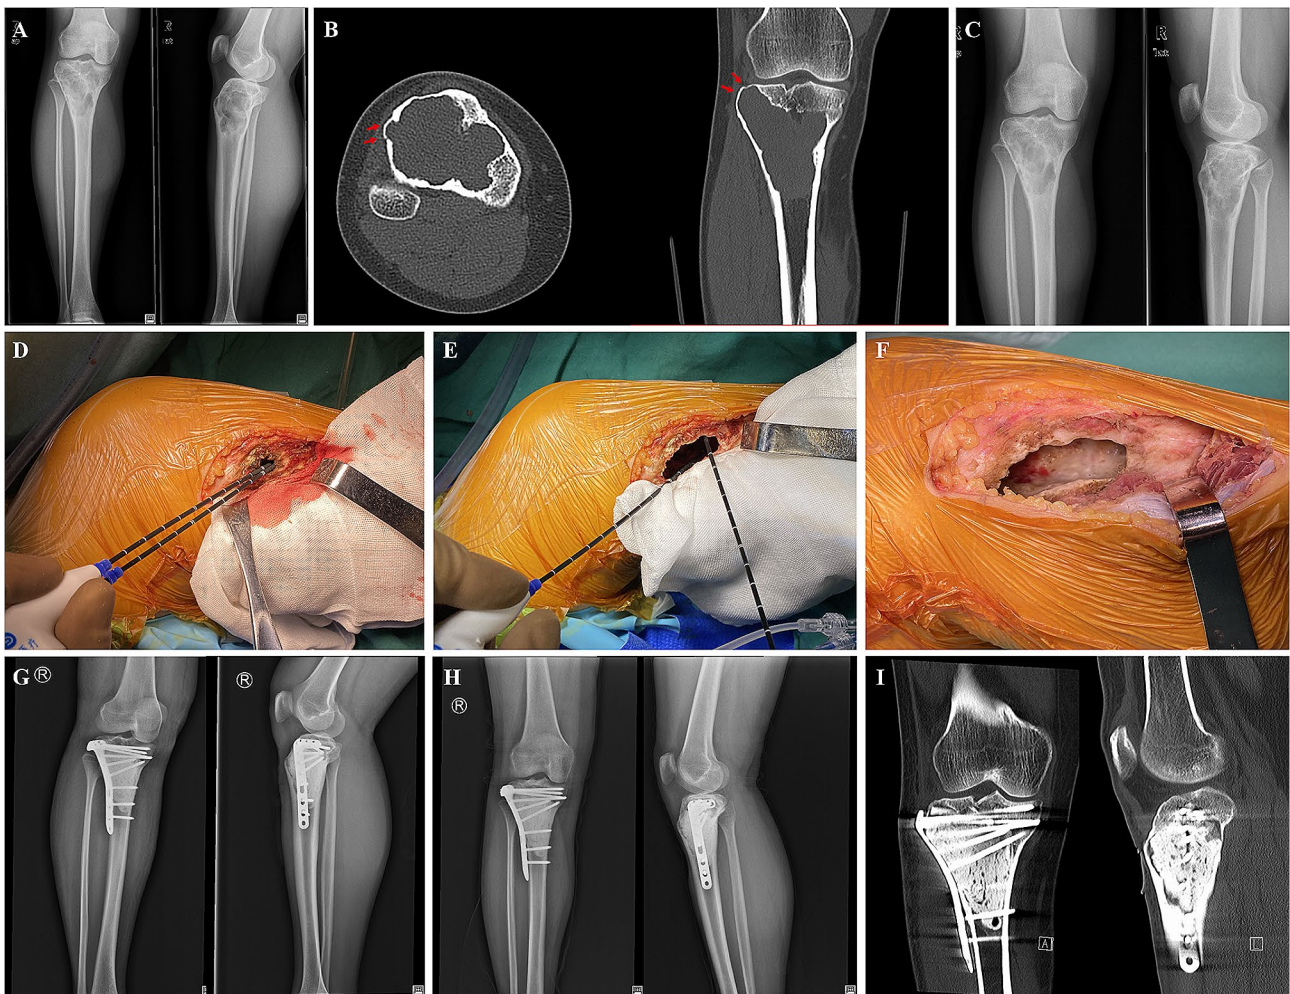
A patient with a giant cell tumor of the proximal tibia was administered two doses of denosumab. An expansile osteolytic lesion with involvement of the cortical bone and articular cartilage as shown by the red arrow was seen on the anteroposterior plain radiograph (A) and CT image (B). After the patient responds to denosumab treatment, there is mineralization within the lesion (C). Two microwave ablation antennas were inserted into the lesion after fully exposing the lesions and protecting the adjacent normal tissues with gauze (D). The microwave antennas were repositioned to ensure overlapping ablation zones and strategically placed at lesion peripheries to achieve a broader ablation margin (E). The extensive curettage was performed through a large cortical bone window to excise all visible regions of the tumor. (F). The cavity was filled with allografts and bone cement with prophylactic internal fixation (G). There was no recurrence on the radiograph (H) and CT image (I) at 29.9 months of follow-up
